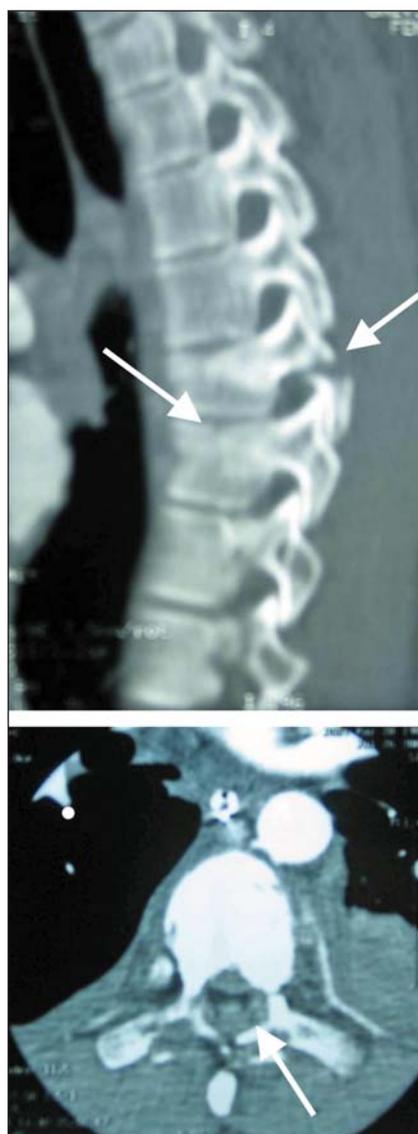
Top: Preoperative CT scan showing fractures of the T7 and T8 vertebrae (arrows). Bottom: Preoperative axial section at the T7 level showing a noncompressing epidural hematoma (arrow).
